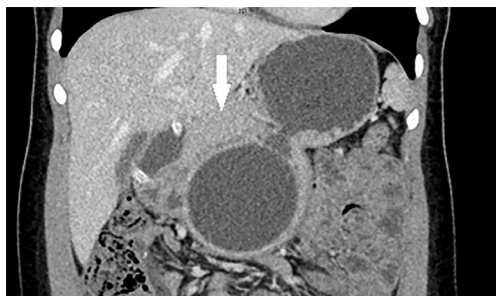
Computed tomography of the coronal plane. The arrow indicates the slightly compressed neck of the pancreas by the balloon.
